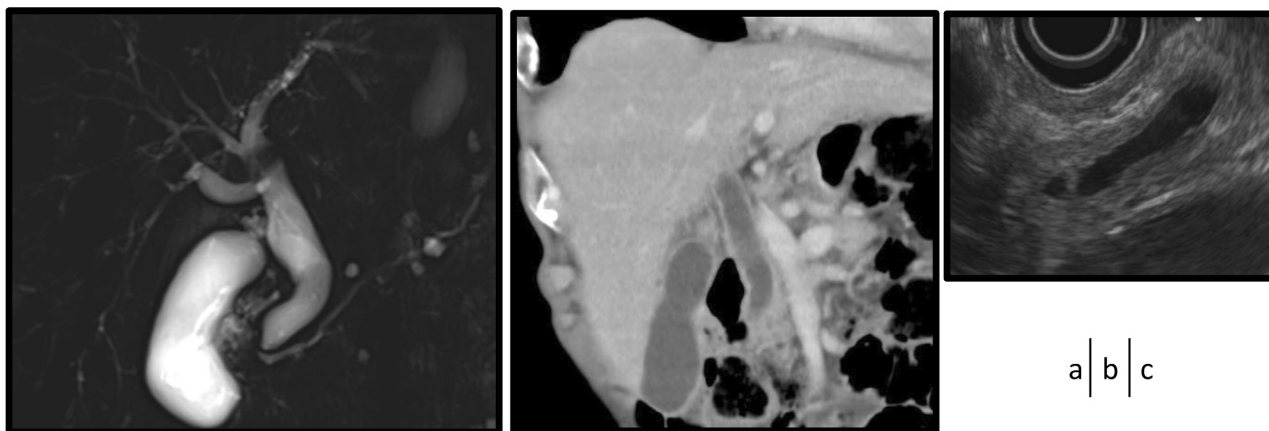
(a) Typical imaging findings in cholangitis induced by immune checkpoint inhibitors magnetic resonance cholangiopancreatography. (b) Contrast-enhanced computed tomography. (c) Endoscopic ultrasonography. The patient was a man aged in his 90s. Cholestatic liver injury with Common Terminology Criteria for Adverse Events grade 3 appeared 442 days after the initial administration of an anti-programmed cell death 1 antibody drug for bladder cancer. Aspartate aminotransferase 249 (U/L), alanine aminotransferase 215 (U/L), alkaline phosphatase (IFCC) 1572 (U/L), and gamma-glutamyltransferase 1010 (U/L). Extrahepatic bile duct dilatation and diffuse thickening of the bile duct wall with no cause of obstruction were observed.
